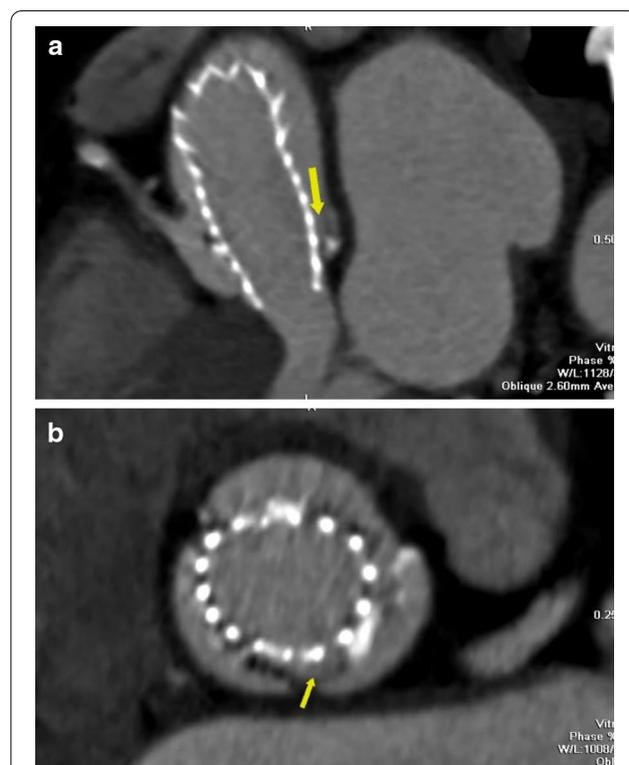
CT aortography for patient presented by post-procedure complications showing paravalvular leak (arrow)
